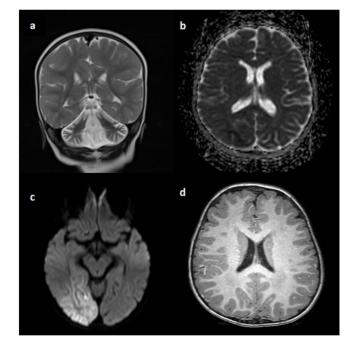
MRI images of patients. a) Cereballar hypoplasia in the patient with pontocereballar hypoplasia type 0, b and c) Difussion restriction in the right occipital region of the patient with MELAS on ADC sequence and diffusion MRI respectively, d) Leukodystrophy in the patient with MLD.
